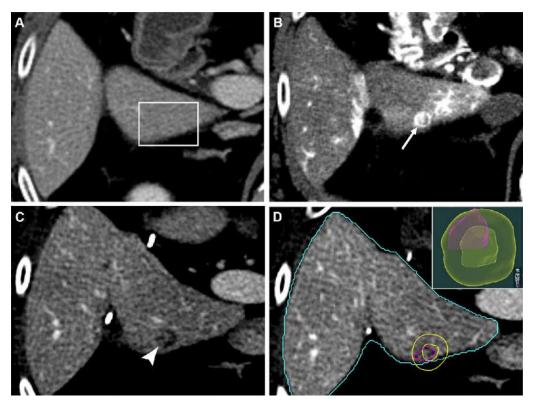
Images in a 50-year-old man who presented with an incidental RHLM (size: 9 mm), which was confirmed to be colorectal liver metastasis at follow-up imaging. (A) Axial CT image during portal venous phase obtained 19 days before the procedure shows no lesion on segment VI (inset). (B) Preablation axial CTHA image in late arterial phase shows one incidental RHLM (arrow). (C) Axial CT image in portal venous phase obtained at first follow-up demonstrates a new hypovascular nodule (arrowhead). A biomechanical deformable image registration method was performed to register and map the incidental RHLM from CTHA to follow-up CT. (D) Axial CTHA image with segmentation shows the liver, incidental RHLM with 5-mm expanded margins, and new hypovascular nodule contours (blue, yellow, and pink, respectively). The new nodule overlaps with the incidental RHLM, which was computed on images with three-dimensional volume rendering (inset). CTHA = CT during hepatic arteriography, RHLM = ring-hyperenhancing liver micronodule.
